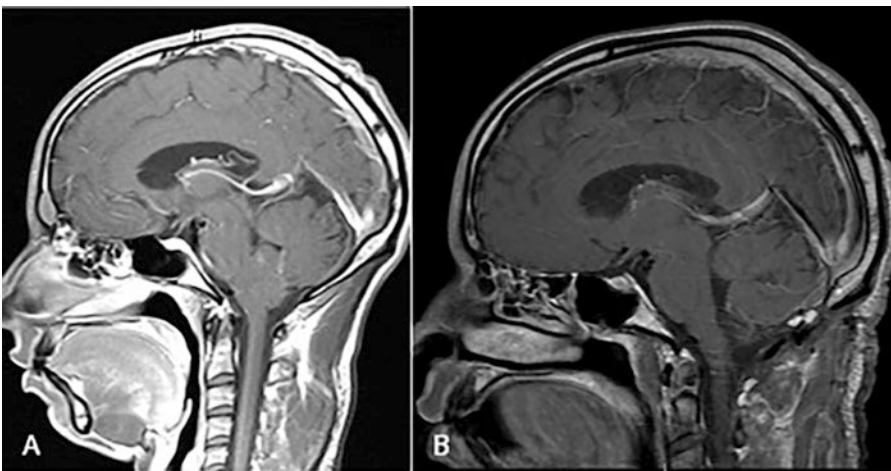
A 39-year-old male patient with severe headaches and balance problems. (a) preoperative T1-weighted post-contrast MRI of the brain which shows the tumor on
